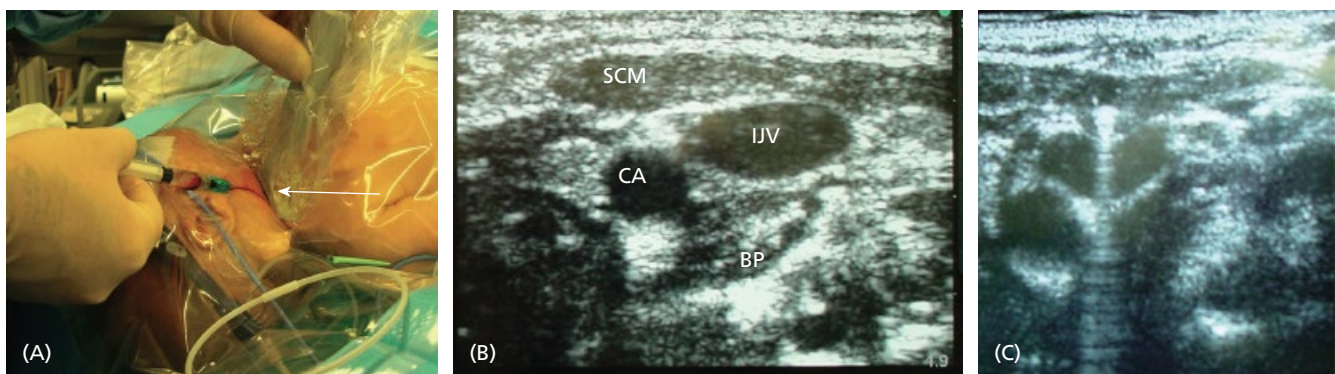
(A) Ultrasound-guided puncture of the internal jugular vein in an infant. The arrow denotes a 13 MHz pediatric probe. (B) Two-dimensional ultrasound view of the right internal jugular vein and carotid artery in an infant. CA, carotid artery; IJV, internal jugular vein; SCM, sternocleidomastoid muscle; BP, brachial plexus. (C) Needle just prior to puncture of the right internal jugular vein.
